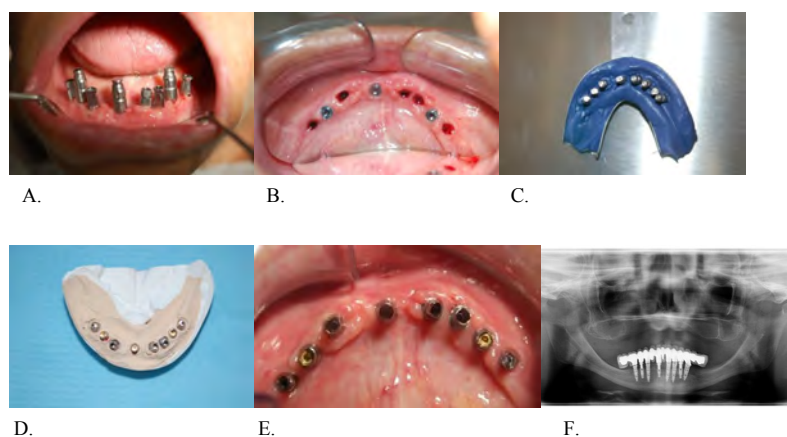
Cemented Technique.* A): Transfer impression; B): Flapples technique; C): Impression. D): Plaster Model; E): Abutments 0°; F): Final X-ray.
